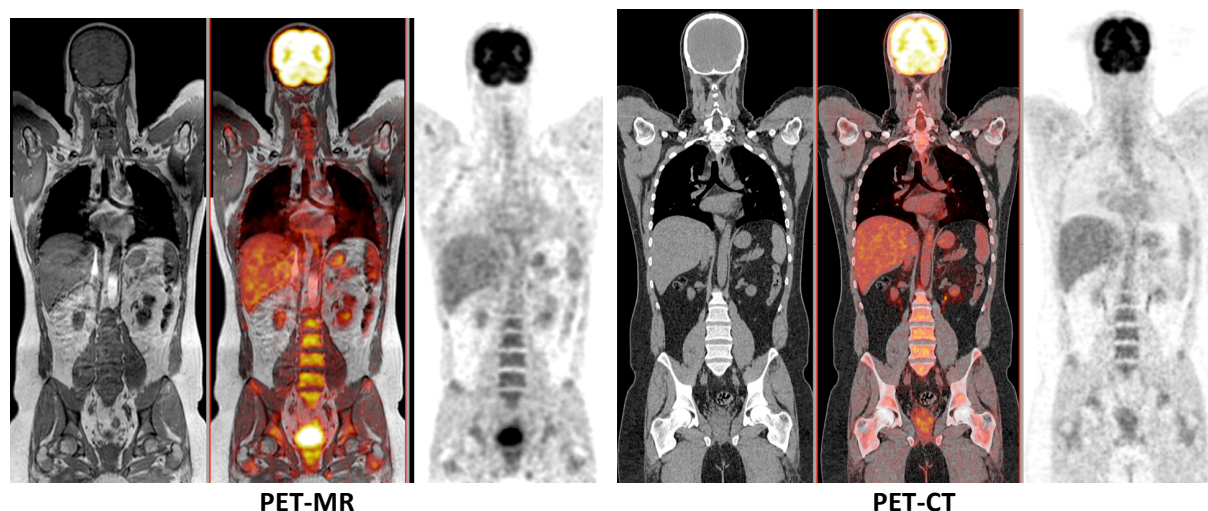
Representative PET-MR and PET-CT images of the same patient acquired sequentially (~60 min time difference) on the two combined systems following injection of 370 MBq of FDG.
